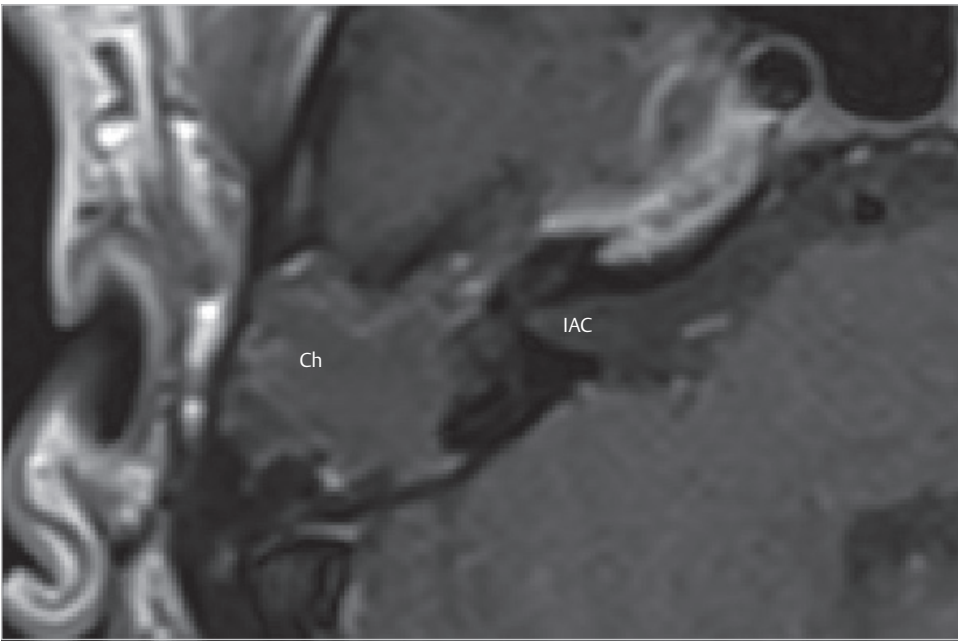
The axial section of T1-weighted image of MRI showed mid signal intensity in the mastoid. Ch, cholesteatoma; IAC, internal auditory canal.
